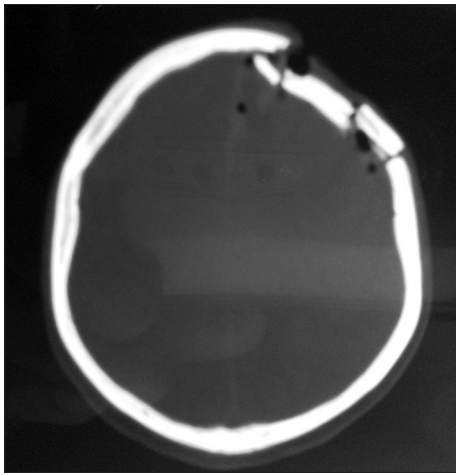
Axial computed tomography (bone window) of a depressed skull fracture
